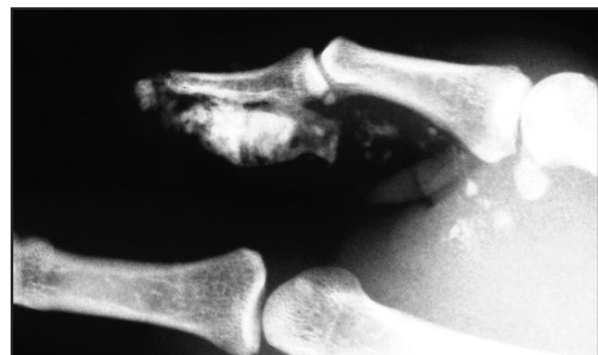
X-ray: radio-opaque paint in region of distal phalanx and tracking down flexor sheath of thumb
